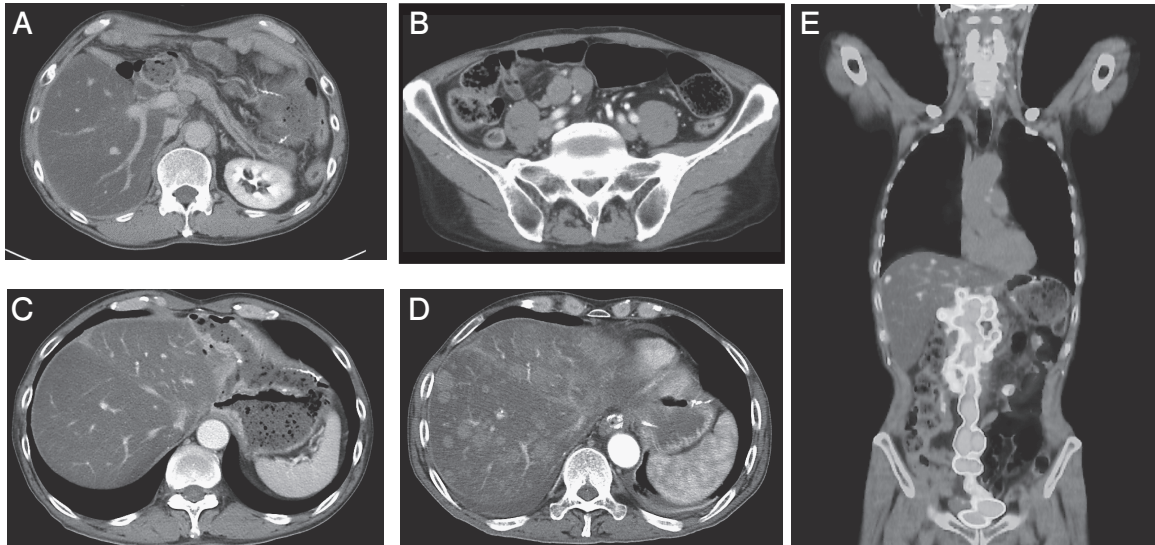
Radiological findings of IgG4-related pancreatitis and malignant lymphoma. Contrast-enhanced abdominal computed tomography (CT) upon admission revealed focal pancreatic enlargement and dilatation of the main pancreatic duct (A). There were multiple mesenteric lymphadenopathies (B). No hepatic space-occupying lesions (SOL) were observed at the time (C). Contrast-enhanced CT of the liver performed 3 weeks after admission showed multiple hepatic lesions, suggesting rapid progression of the disease (D). ^{18}F -fludeoxyglucose positron emission tomography/CT revealed diffuse involvement of para-aortic and mesenteric lymph nodes (E).
